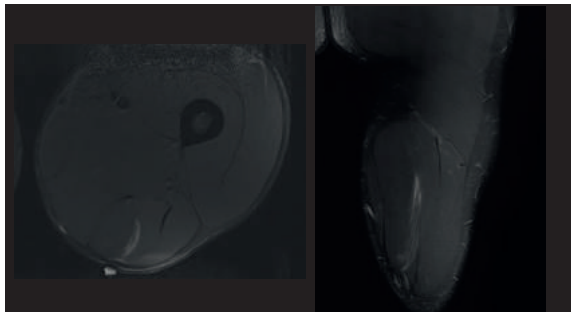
(Case #5). MTJ strain of the semitendinosus raphe. As MRI signs we find periraphe oedema and very slight amount of intermuscular fluid/haemorrhage.
